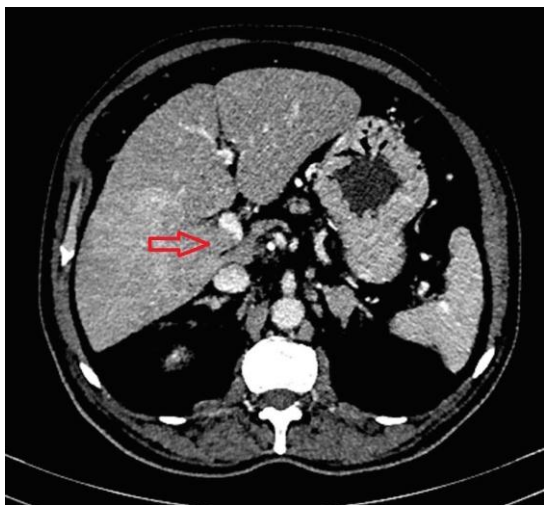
Axial soft-tissue window CT images during portal & venous phases showing an enhancing thrombus in portal vein extending into right branch of portal vein (marked with red arrow).
